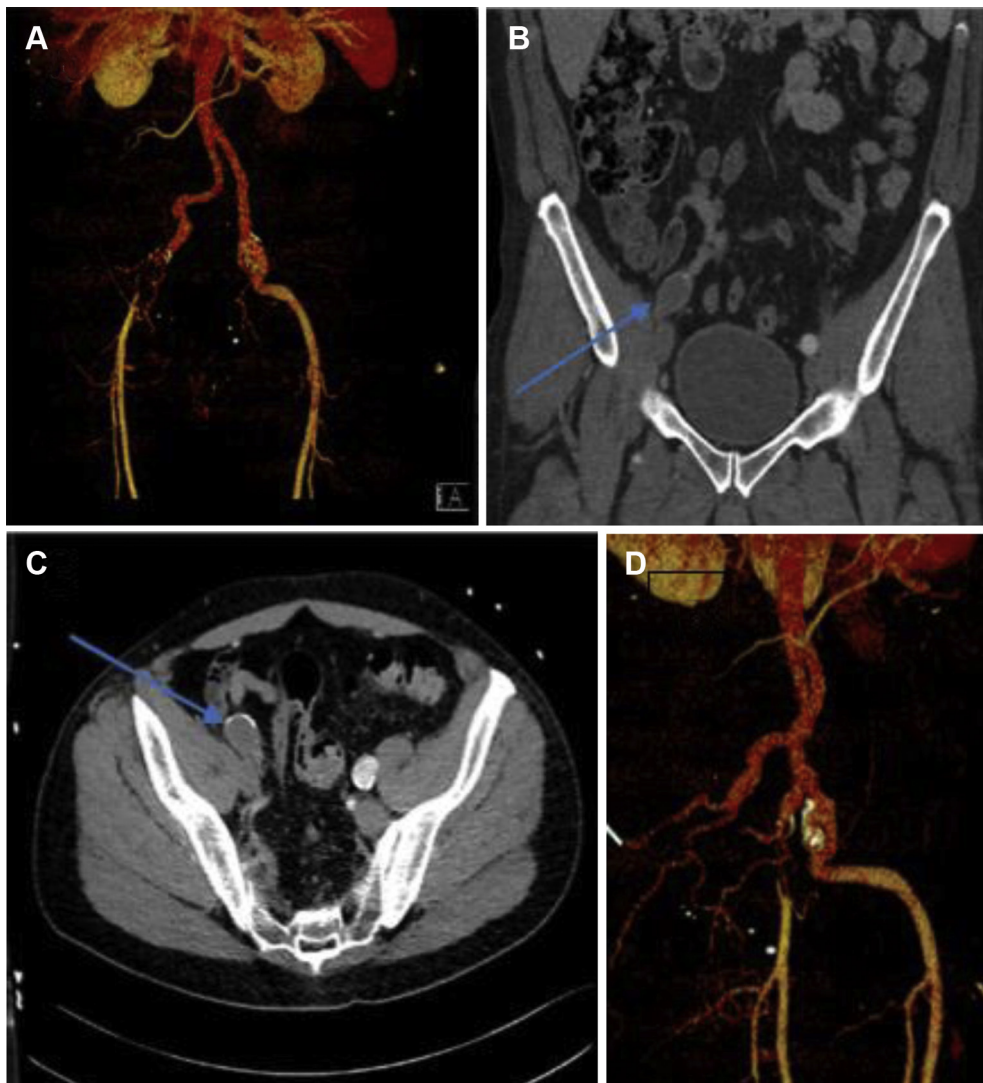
A-D, Computed tomography (CT) angiography in axial (C) and coronal (B) view with three-dimensional reconstruction (A and D) shows the isolated 2-cm large thrombosed aneurysm of the right external iliac artery (EIA) (blue arrow) and the 2-cm large sacciform aneurysm of the left EIA (white arrow).
